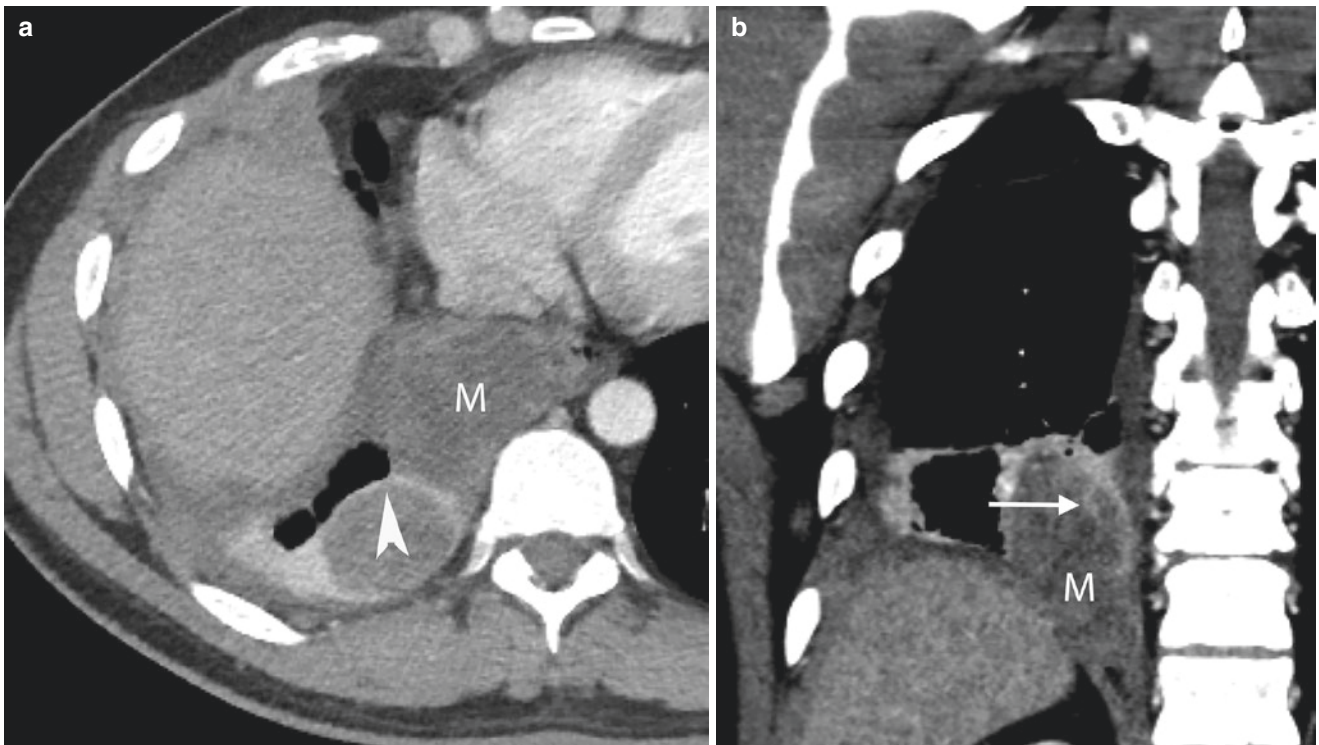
Pleural synovial angiosarcoma. (a, b) Contrast-enhanced axial and coronal CT shows a heterogeneous mass (M) in the right lower hemithorax with areas demonstrating peripheral enhancement (arrowhead) and thin internal enhancing septation (arrow)
